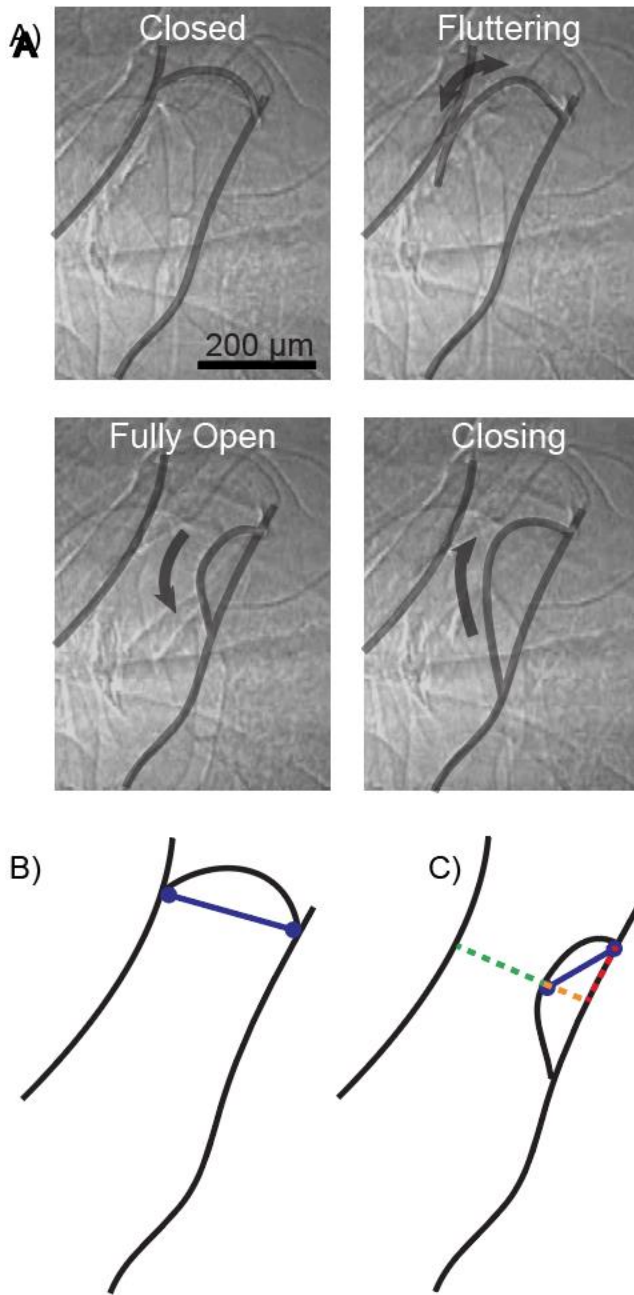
A: X-ray video frame of an abdominal spiracle demonstrating both fluttering and complete opening behavior. The image has been annotated for clarity. B: Technique for directly assessing the available area for flow through the spiracle manifold. A “default” state representing a fully closed spiracle is measured from the hinge of the spiracle flap to the opposite wall (blue line) C: As the spiracle moves through its opening arc, the line is redrawn to extend from the hinge to the point on the flap closest to the abdominal wall (blue wall). By comparing the length and angles of these two lines, it is possible to estimate the remaining area available for airflow (orange, red, and green lines).
